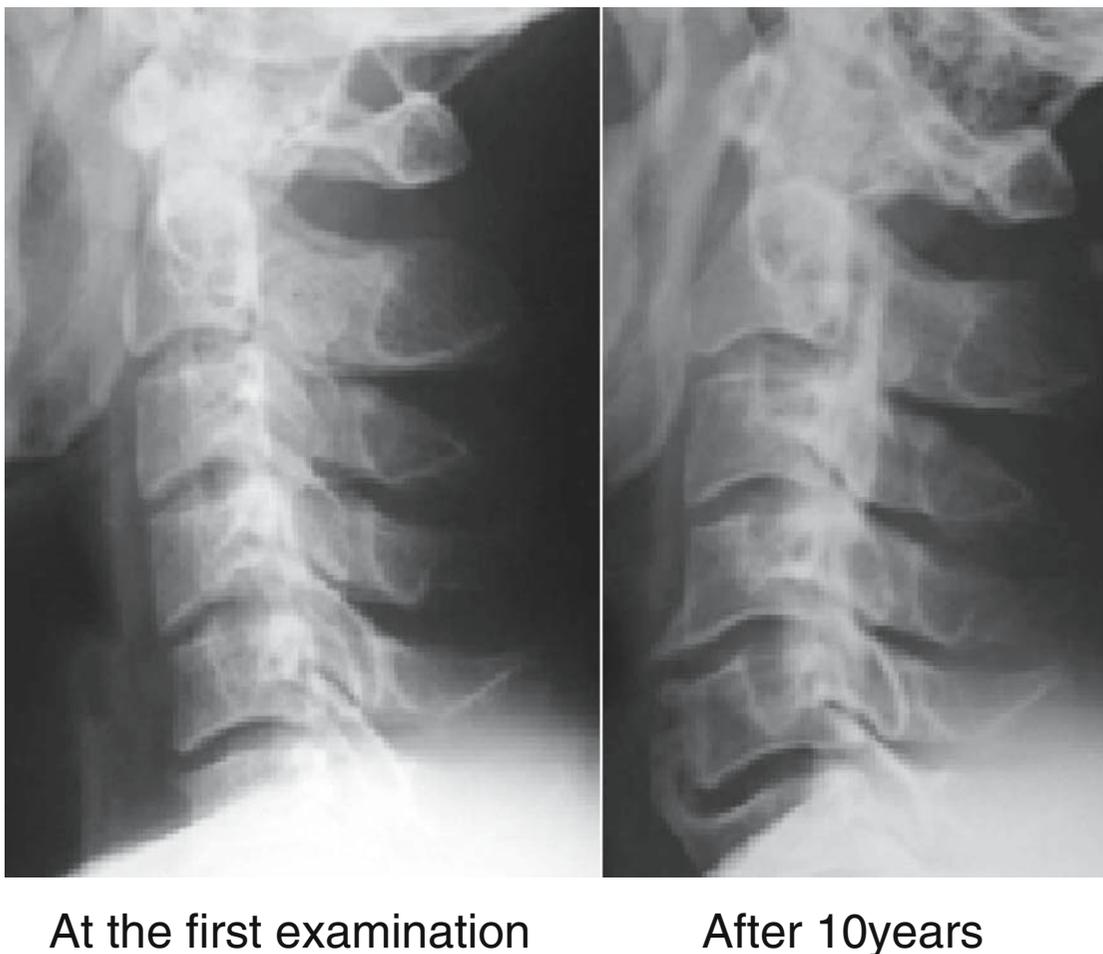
Lateral plain radiograph shows marked development of ossification of the posterior longitudinal ligament (OPLL) at the 10-year follow-up
